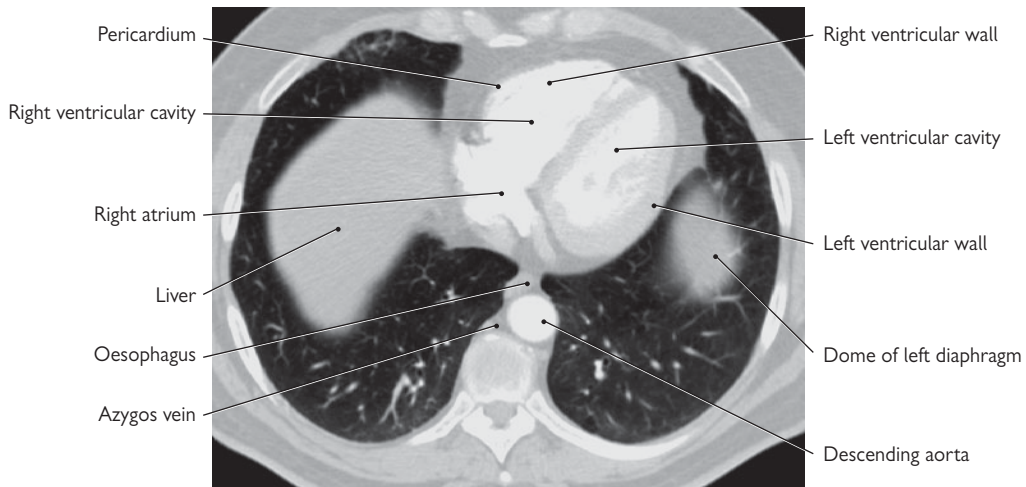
CT anatomy of the thorax: level of T6.
